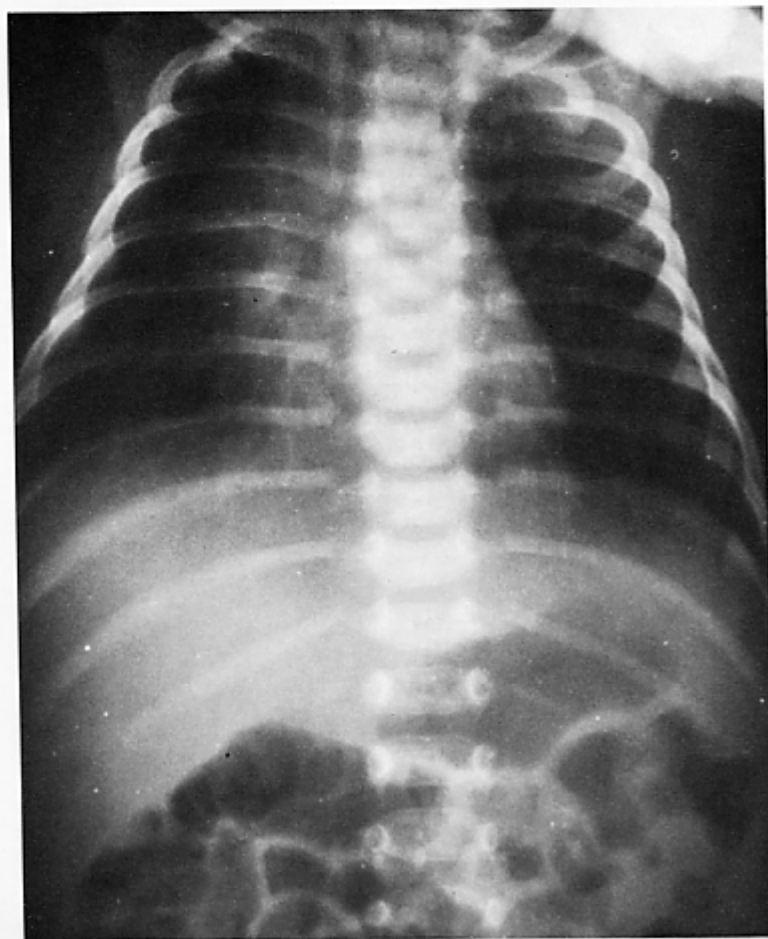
Chest x-ray film after two months.
